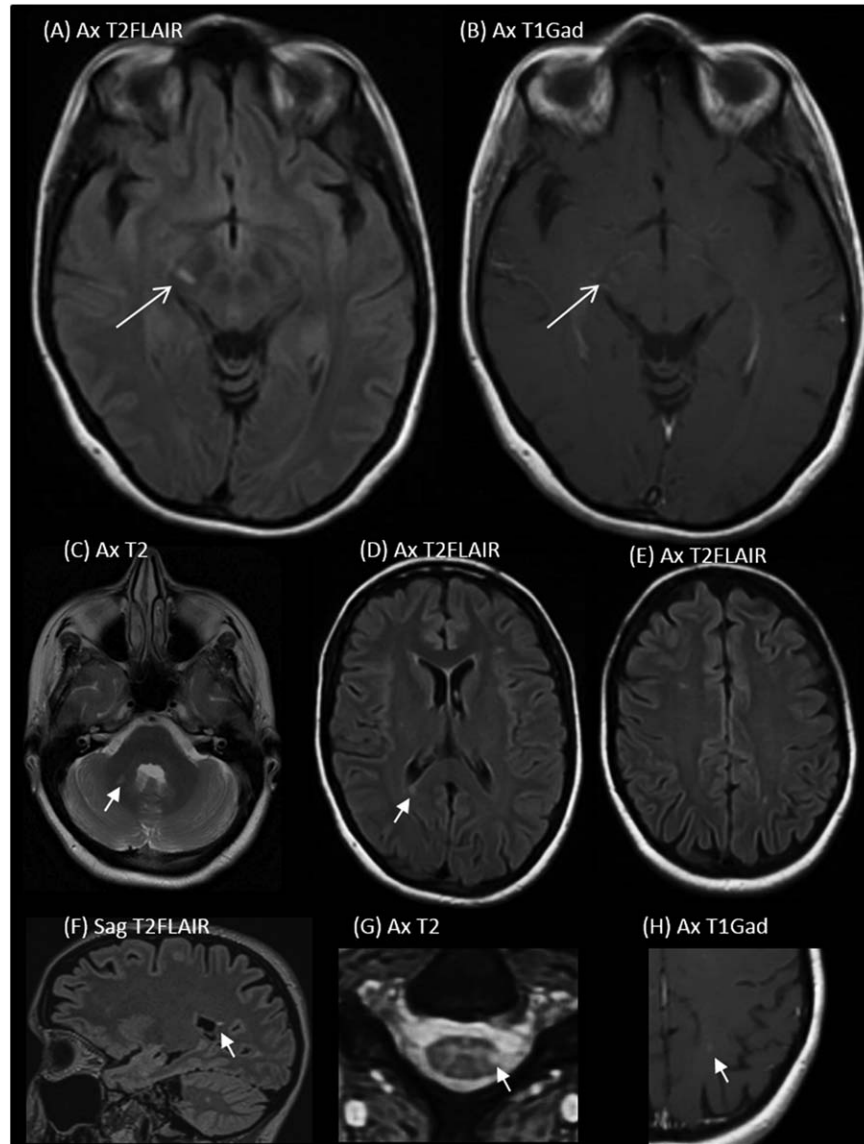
(A-B) Brain MRI (T2) showing a right cerebral peduncle (pyramidal tract) lesion with gadolinium enhancement assumed to cause the tonic spasms; (C-H) white matter lesions with 2010 McDonald criteria for dissemination in space and time (one enhancing, asymptomatic lesion, H).
